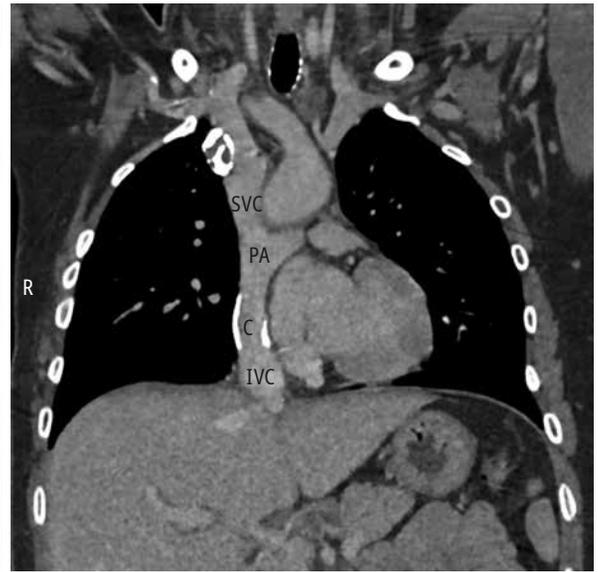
Computed tomography: a coronal reformat image showing the extracardiac conduit of the total cavopulmonary connection
